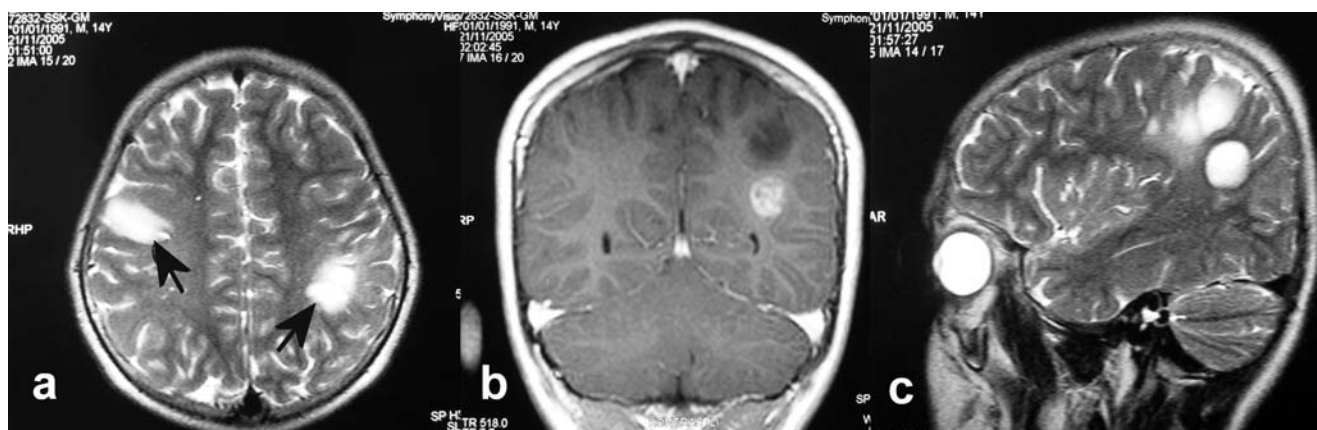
a T2-weighted axial MRI scan demonstrates two well-demarcated lesions (arrows) localized in the left posterior parietal and right frontal regions. b T1-weighted contrast-enhanced coronal and c T2-weighted sagittal MRI images
